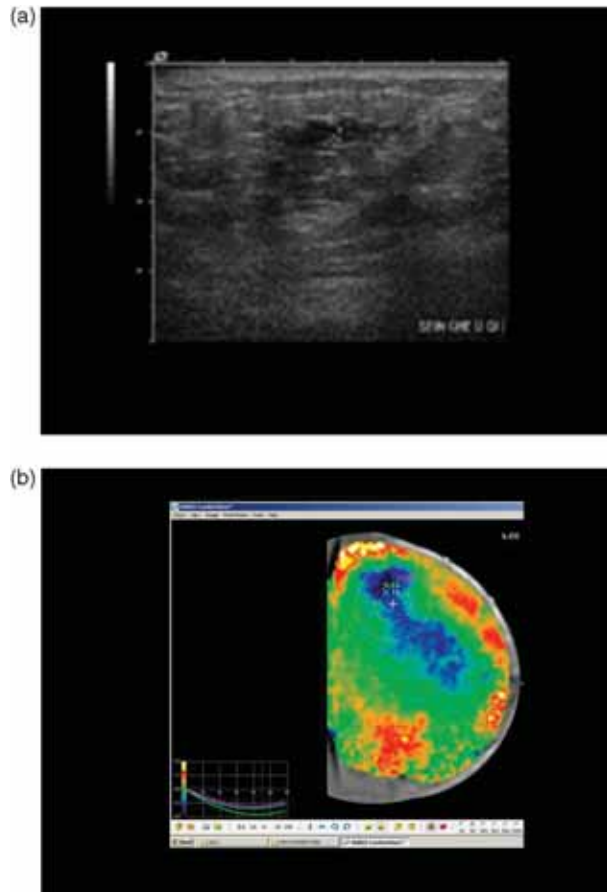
Case 4. (a) Breast ultrasound with a 10 mHz probe depicts a hypoechoic micro-lobulated nodular lesion in a woman presenting with metastatic axillary lymphadenopathy and negative mammography. This lesion was initially considered as clustered micro-cysts. (b) Dynamic optical mammography reveals a highly hypoxic blue area with negative curves, corresponding to the ultrasound lesion localization. Biopsy under ultrasound guidance revealed infiltrating lobular carcinoma.
